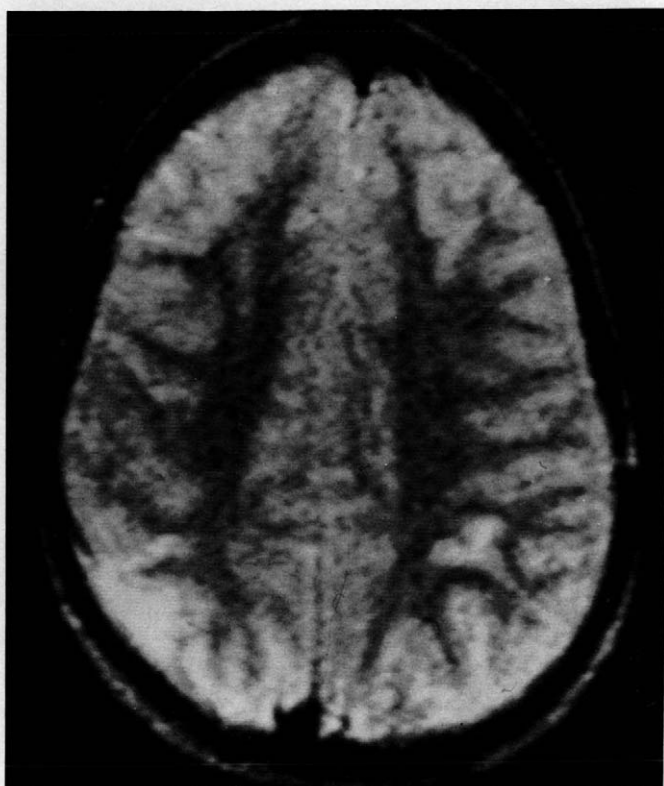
MRI showing a fresh ischemic infarct in white matter of left parietal lobe and an old infarct in the right posterior temporoparietal lobe. This MRI was obtained after the revascularization procedure.
